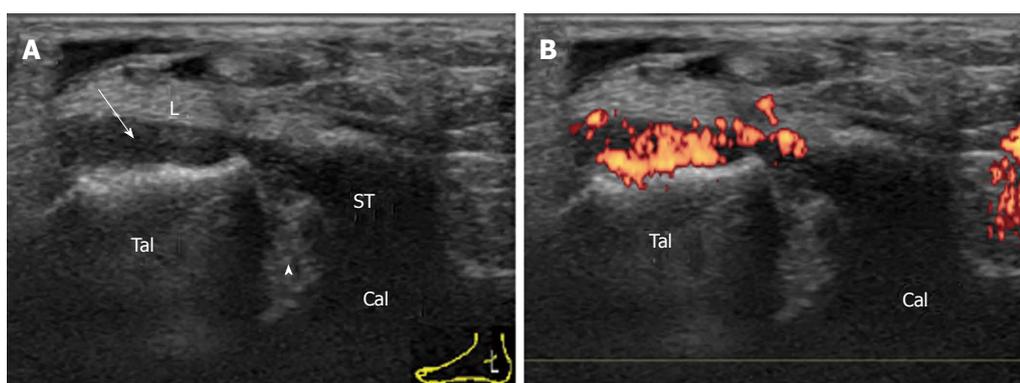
Synovitis of the posterior subtalar joint in rheumatoid arthritis. Coronal grey-scale (A) and power Doppler (B) sonogram of the medial facet (arrowhead) of the PSTJ. PD-signal-positive proliferated synovium (arrow) of the PSTJ stretches cranially along the tibiocalcaneal ligament (L). Tal: Talus; Cal: Calcaneus; ST: Sustentaculum tali; PSTJ: Posterior subtalar joint.
